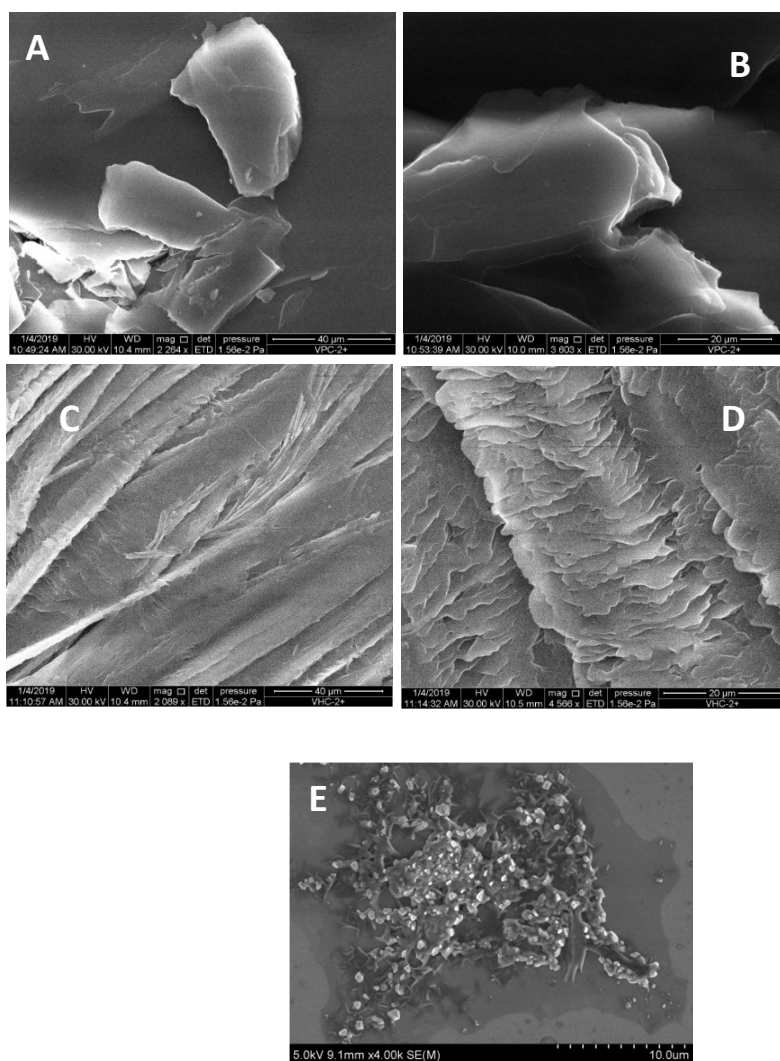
SEM Images of (A) and (B) - V1, (C) and (D) - V2, (E) – [V4-Pyr] CT complex
